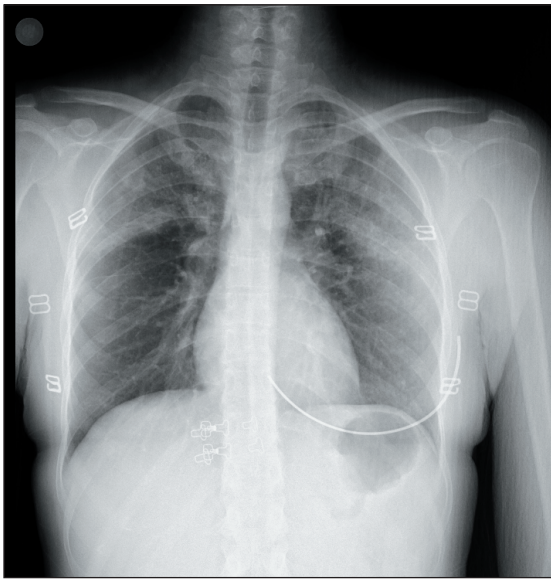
Pre-treatment postero-anterior chest radiograph showing bilateral peripheral consolidations consistent with active ICEP.
